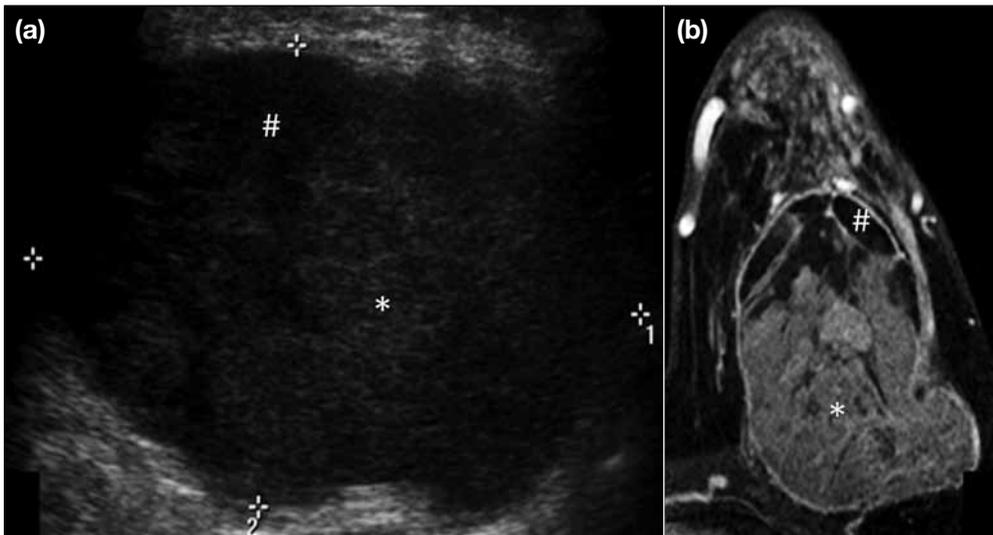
(a) Ultrasound image of the left breast of a 61-year-old woman showing a complex cystic (#) and solid (*) lesion that was oval with indistinct margins (calipers), located in the superolateral quadrant. (b) T1-weighted magnetic resonance image after intravenous contrast injection (dynamic study) showing a complex cystic (#) and solid (*) mass with enhancement of the solid portion, occupying the superolateral quadrant.
